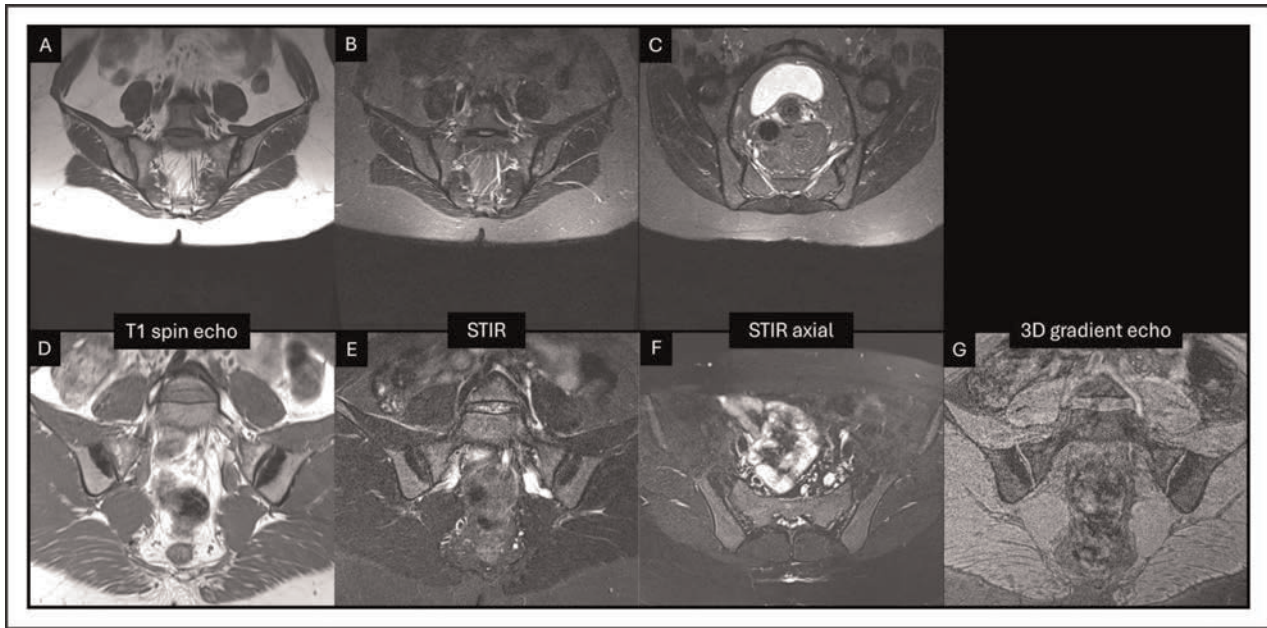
Two female patients with osteitis condensans ilii were scanned on the same type of 10-year-old Siemens 1.5 Tesla scanner. MRI images a–c were acquired in July 2025 in local clinical practice and represent a typical SIJ MRI protocol that has been in place for over 20 years. Images are generally adequate, but scanning at 300 mm fields of view provides limited spatial resolution, and the possibility of erosion in the left ilium is hard to interpret. MRI images d–g were acquired during the CLASSIC study according to the ASAS/SPARTAN protocol, which mandates the inclusion of a thin slice T1-weighted erosion-sensitive sequence. In this case, the semicoronal sequences are scanned at smaller fields of view (a –250 mm, b –280 mm, d – 220 mm) and the 1.5 mm thick 3D gradient echo sequence is reassuring that no significant erosion is present (images D–G provided with permission of SPARTAN). ASAS, Assessment of Spondyloarthritis International Society; SIJ, sacroiliac joint; SPARTAN, Spondyloarthritis Research and Treatment Network protocol.
